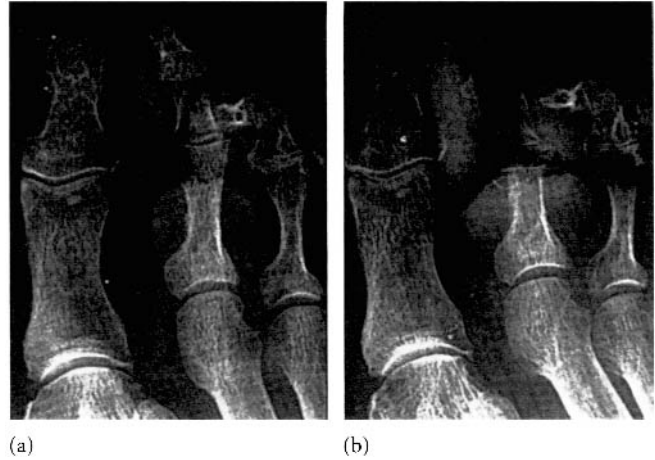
(a) The X-ray shows intact distal phalanx of the 2nd toe. (b) Destruction of the distal phalanx 2 weeks later indicative of osteomyelitis.
